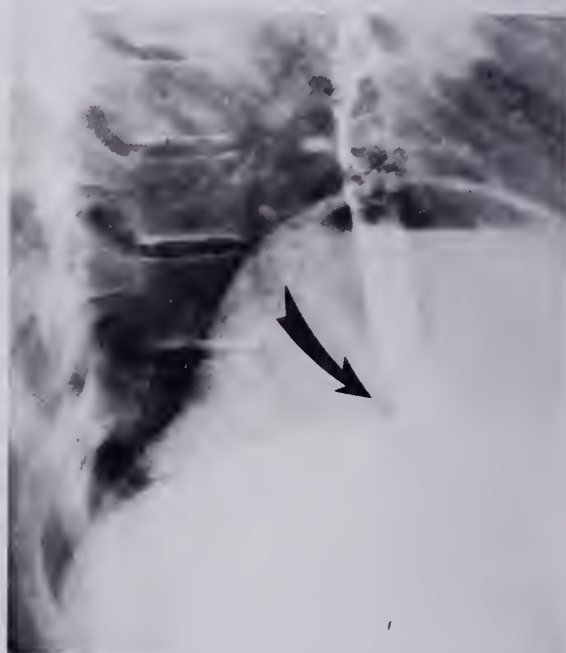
(Case 3).—Barium x-ray demonstrates gastroesophageal junction in position below diaphragm while gastric air fluid level is above diaphragm.
